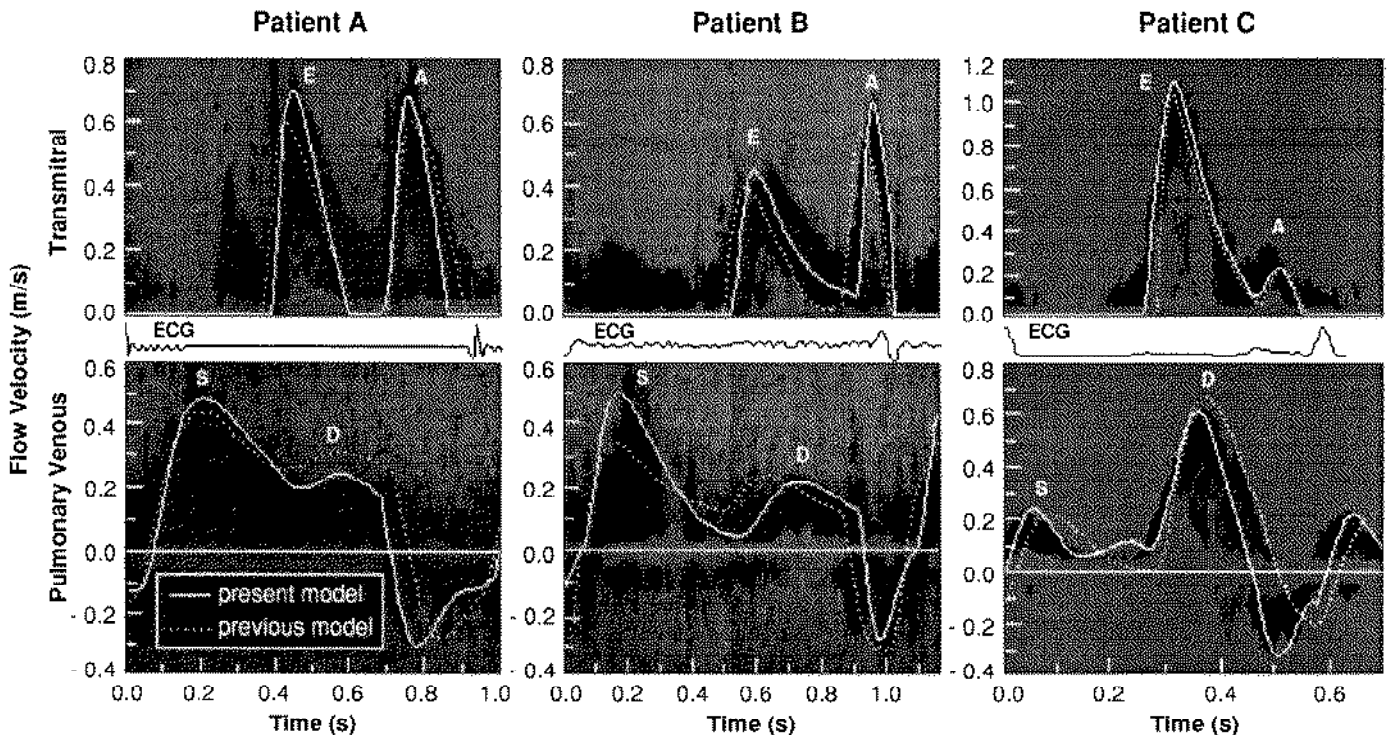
Pulsed-Doppler echocardiographic recordings from 3 patients on which are superimposed waveforms fitted with present model and previous model, which does not include right heart dynamics.
